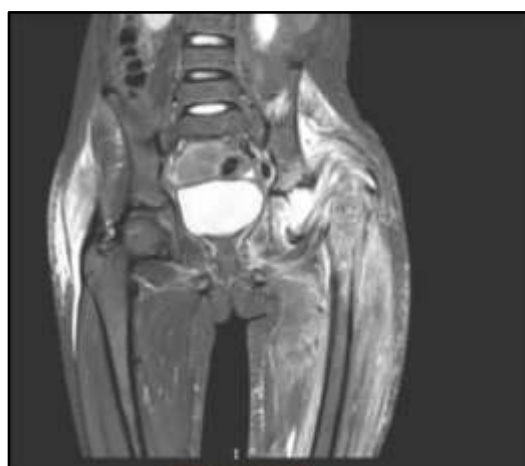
MRI CORONAL STIR Image shows Bone Marrow Oedema of Femur and Acetabulum, Dislocation of Left Hip with Pseudoarthrosis, Oedematous Surrounding Soft Tissue and Abscess in Patient with Tuberculosis Hip
